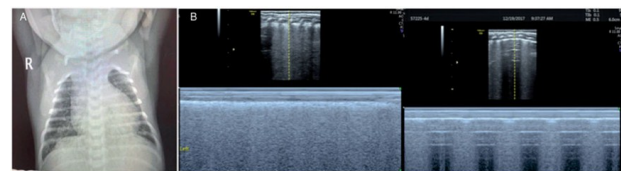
The chest X-ray (CXR) exhibits an increase in pulmonary markings with a blurred pattern, and a distinct "spinning top-shaped" shadow is clearly visible. Signs of pneumothorax (A) are detected. Lung ultrasonography (LUS, M-mode): The left lung reveals the presence of "comet tail artifacts," while the right lung exhibits the typical "lung point" sign, confirming the presence of right-sided pneumothorax (B).
